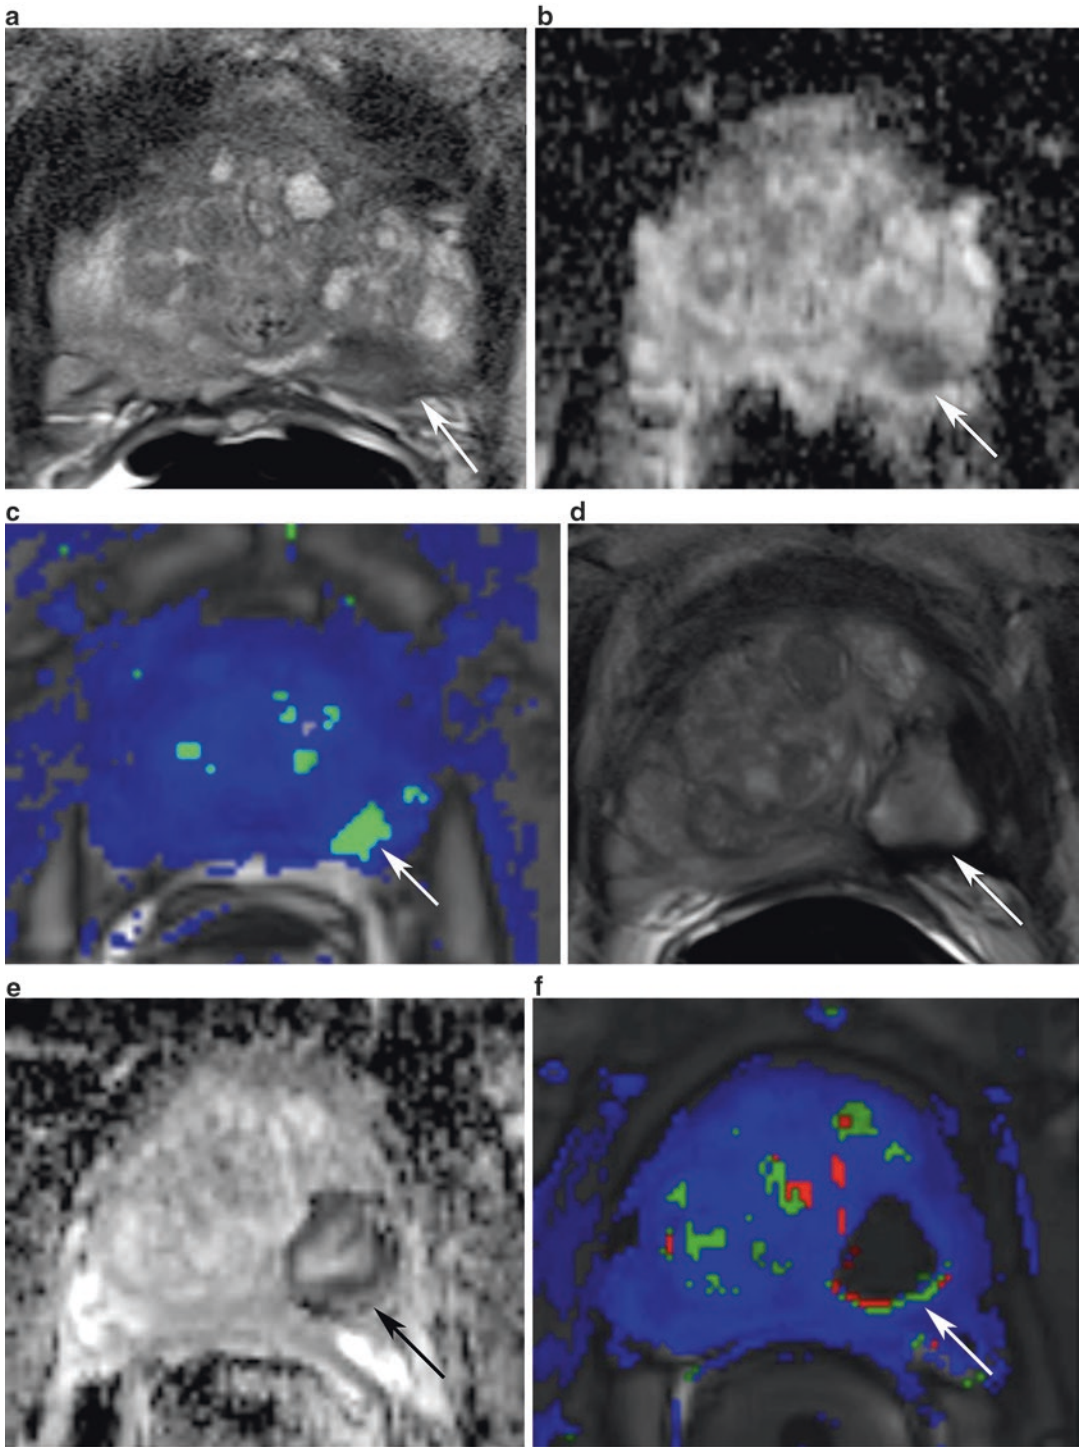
A 72-year-old man with serum prostate-specific antigen (PSA) of 25 ng/mL and history of three negative systematic biopsies was referred for multiparametric magnetic resonance imaging (mpMRI) to assess for clinically significant prostate cancer. (a) Axial T2W images show a lesion with low T2 signal intensity in the left posterior medial and lateral peripheral zone (PZ) (arrow). There is also extensive benign prostatic hypertrophy (BPH). (b) Axial apparent diffusion coefficient (ADC) map shows a corresponding area of restricted diffusion (arrow). (c) Colorized perfusion images show suspicious enhancement of the lesion relative to the remainder of the gland. PI-RADS score
